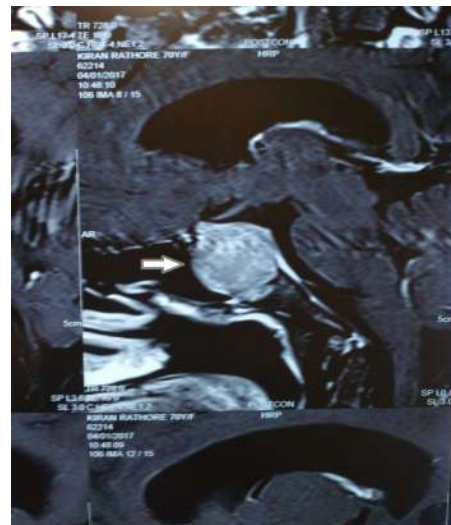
A MRI of the pituitary was advised
